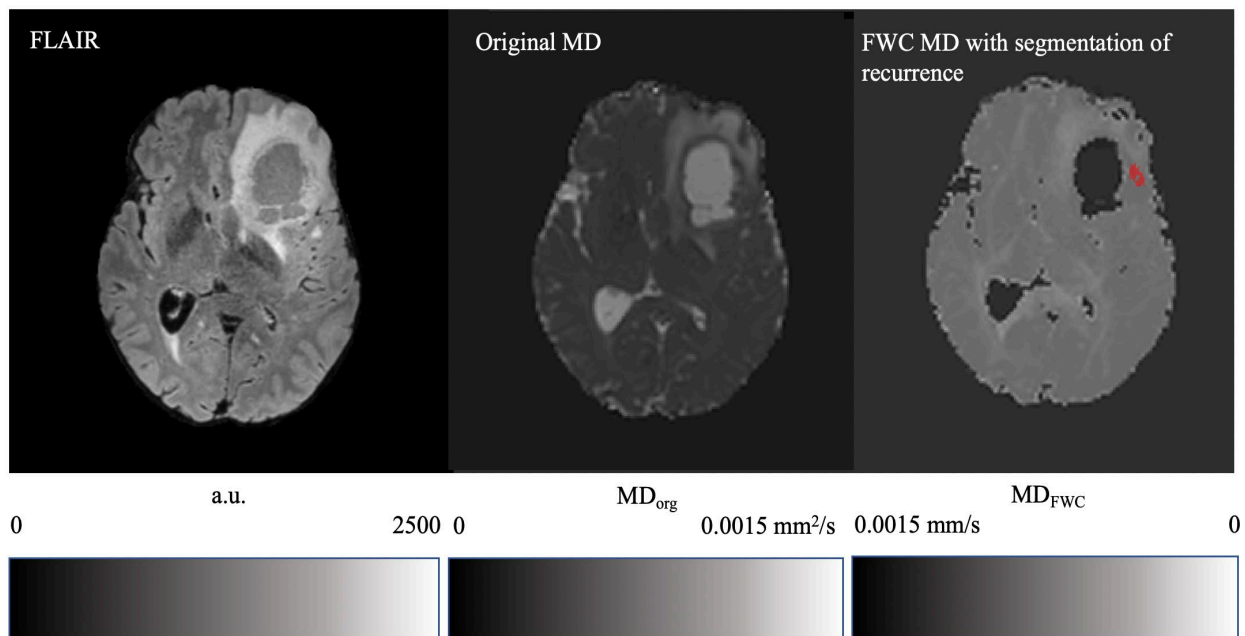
Mean Diffusivity maps of a preoperative MRI examination. For reference, a FLAIR image showing the tumor region is depicted on the left. Since FWC clearly decreases contrast, in the FWC MD map showed on the right, contrast is inverted to ease evaluation.
